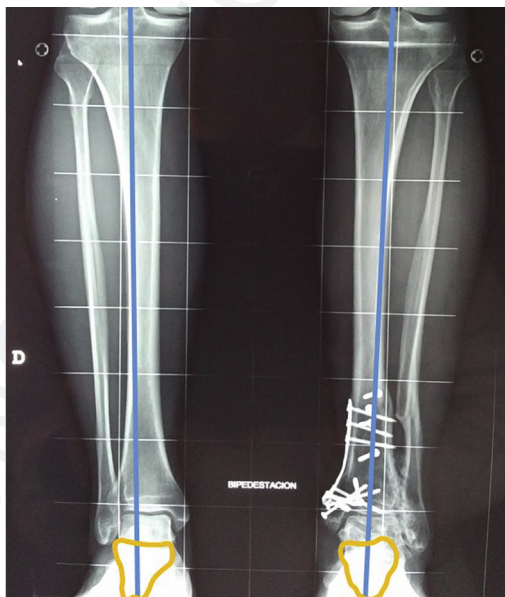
AP weight-bearing leg radiographs of the same patient shown in Fig. 5. A valgusizing SMOT was performed on the left leg (right side of the image) achieving a medialization of the weight-bearing axis (note where the blue line crosses the ankle joint). A good clinical result was achieved and lasted for 10 years.
